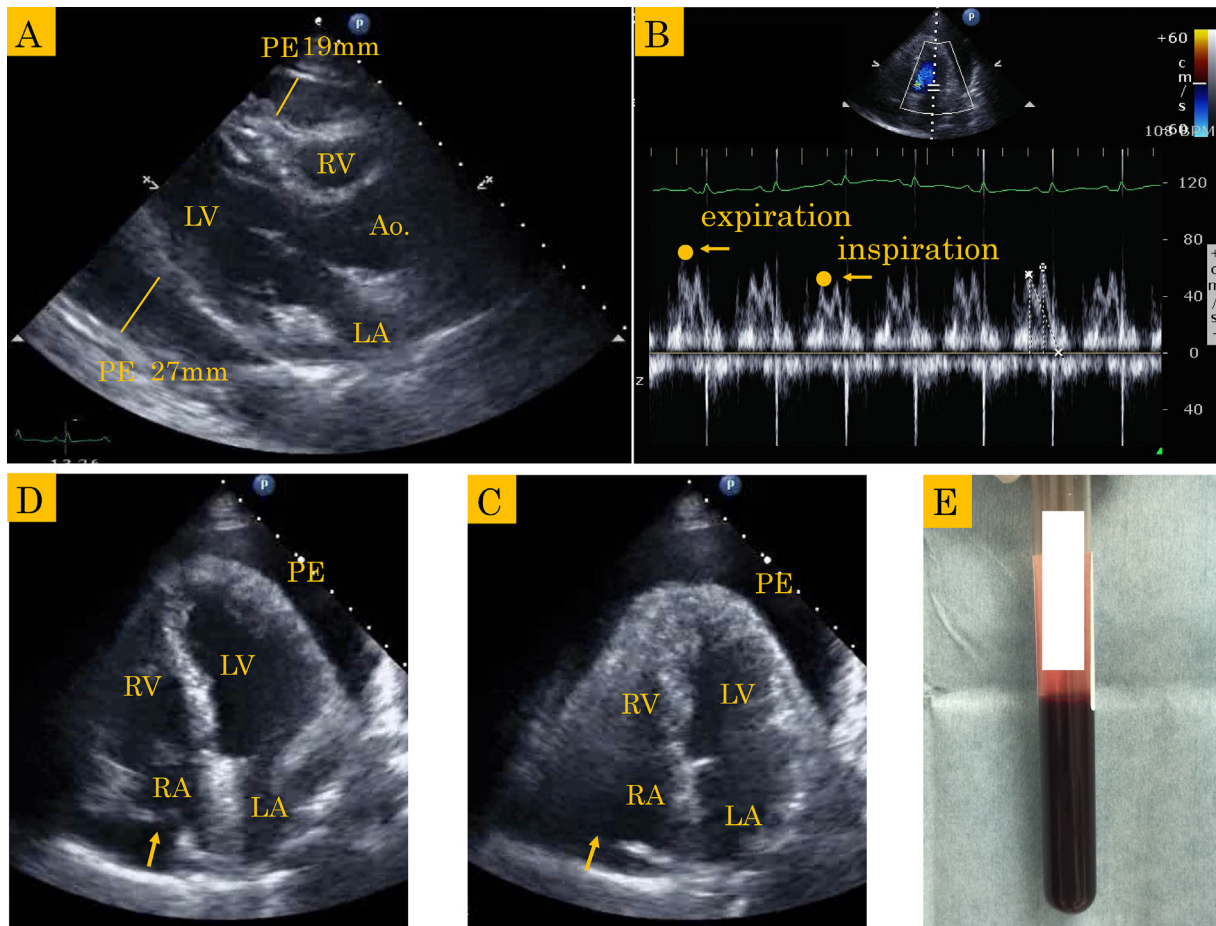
(A) Transthoracic echocardiography revealed that in the end-diastolic phase on parasternal long-axis view, massive pericardial effusion was observed anteriorly and posteriorly (19 and 27 mm, respectively). (B) The transmitral E wave was 68/49 cm/sec (expiration/inspiration), and the respiratory fluctuation rate was greater than 25%. (C) During the diastolic phase, RA collapse sign was observed. On the other hand, (D) during the systolic phase, RA collapse sign was not observed. (E) Pericardiocentesis was performed for diagnosis and treatment, and bloody pericardial effusion was observed. PE, pericardial effusion; RV, right ventricular; LV, left ventricular; Ao, ascending aorta; LA, left atrial; RA, right atrial.
